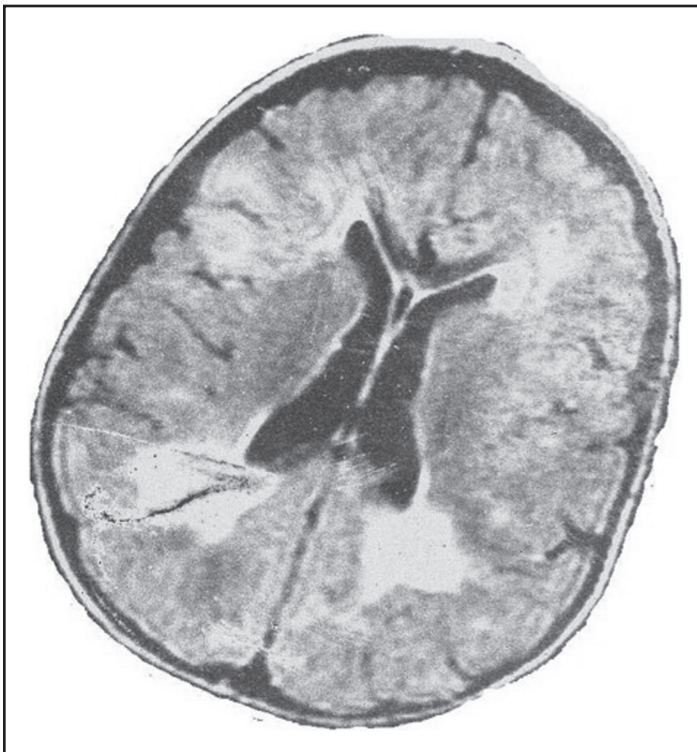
MRI of CM's brain at 23 months of age.
